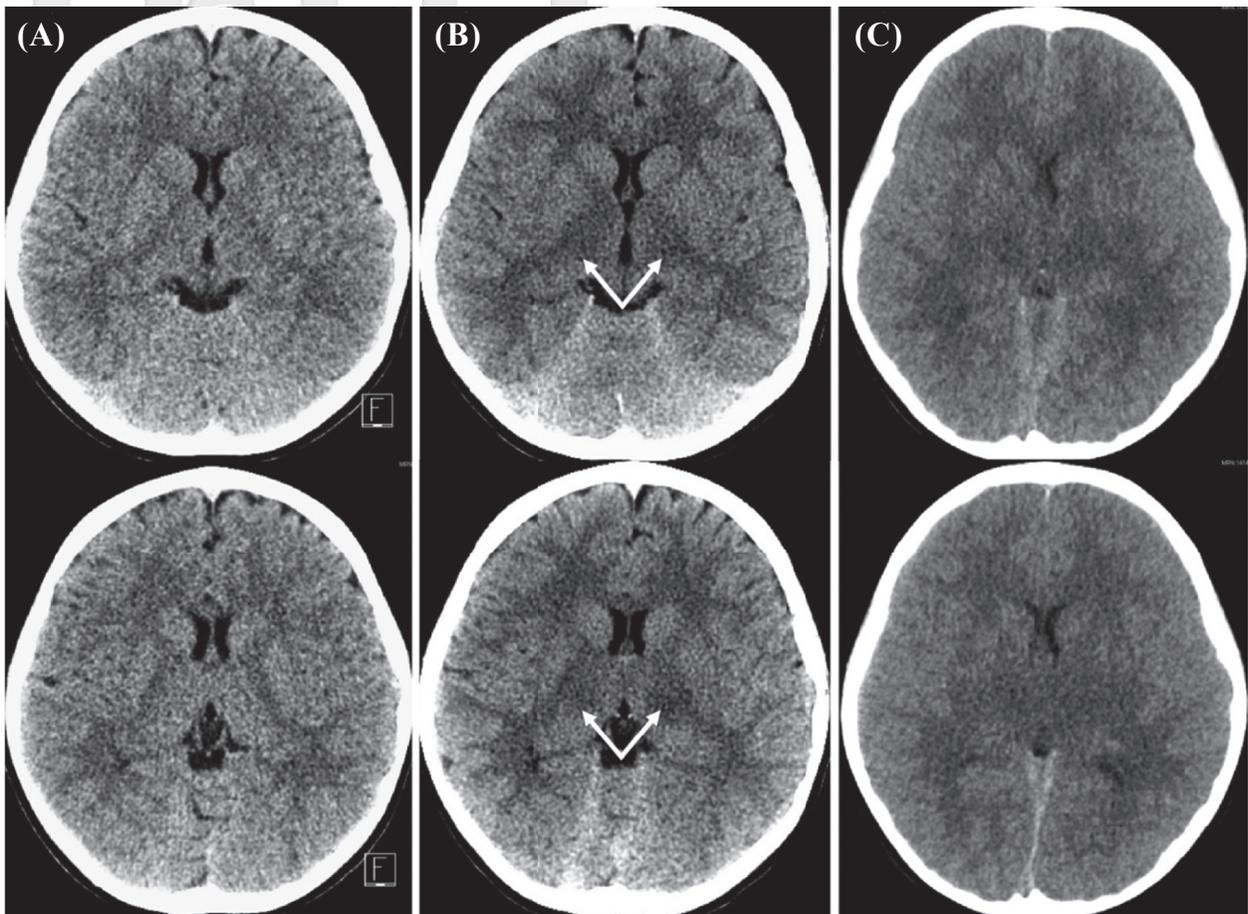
(A) The previous brain computed tomography (CT) (nine months ago) shows the normal brain parenchyma. (B) The first CT scan of the emergency department shows bilateral thalami (arrows) and white matter edematous and hypodense change. (C) The second CT scan (six hours after the first CT scan) shows diffuse brain swelling and ischemic change.
